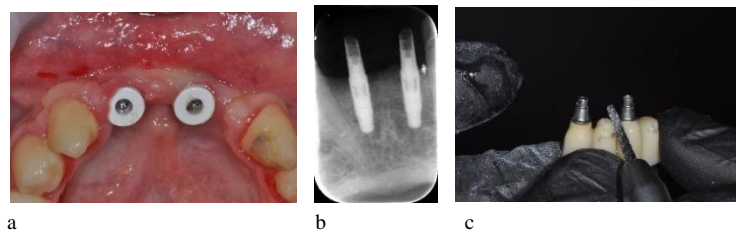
A): healing screws placement after implants osteointegration; B): radiographic control during provisional crowns placement; C): preparation of provisional crowns according to the Loi technique.
